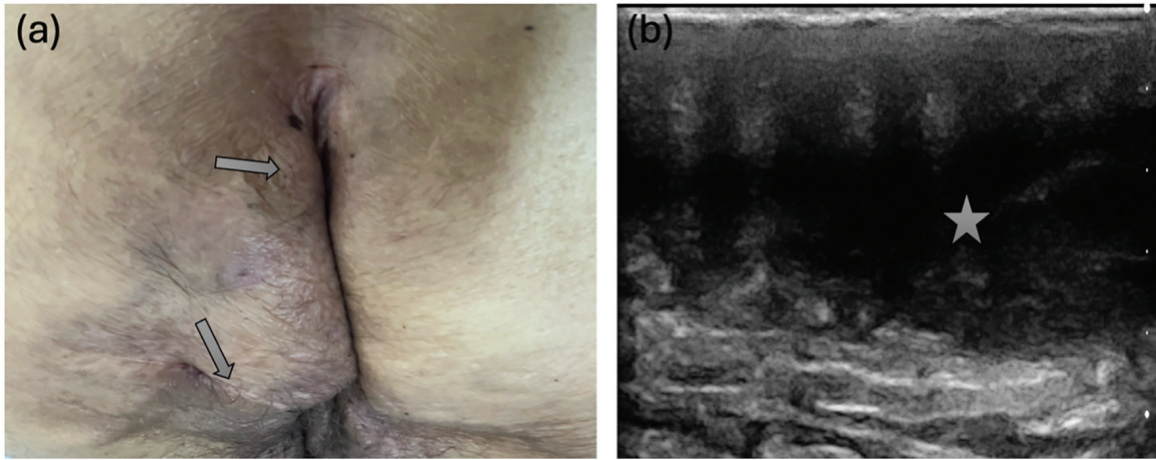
(a) Draining tunnels in the glutea (arrow), (b) ultrasonographic image sinus tract (star) in the glutea
